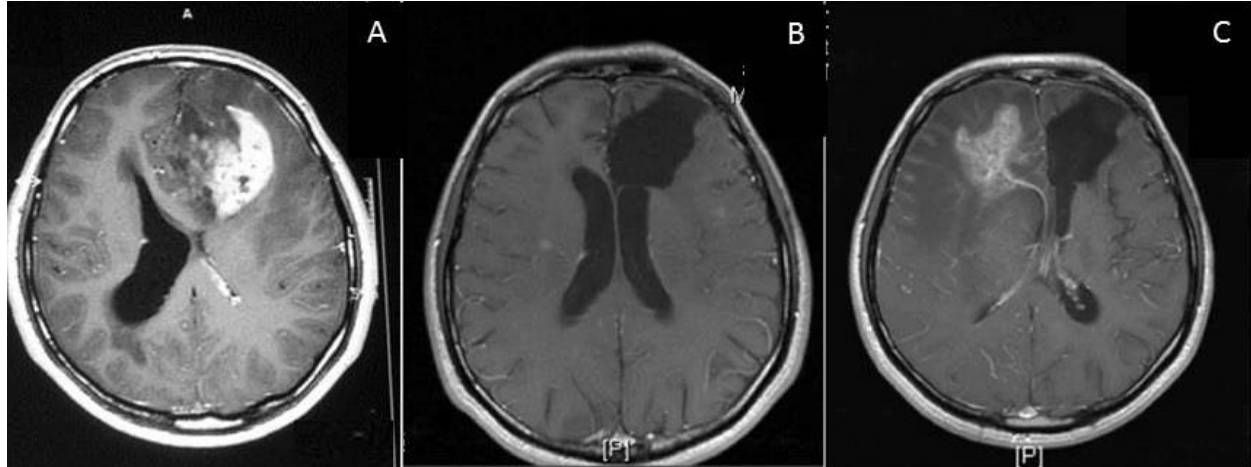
MRI of a GBM patient. A. Before surgery B. After surgery C. Recurrence of tumor 18 months of therapy (MRI scan, kind gift from Prof. Dr. Ihsan Solaroglu)
